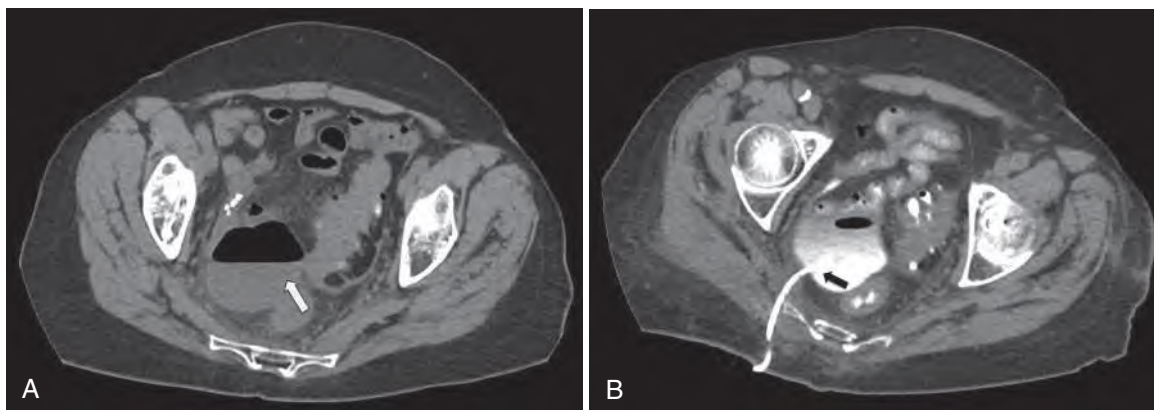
Computed tomographic scans of abdomen-pelvis. (A) Perforated diverticulitis: pelvic collection with an air-fluid level (white arrow). (B) Same patient after interventional percutaneous drain placement of the diverticular abscess (black arrow).
